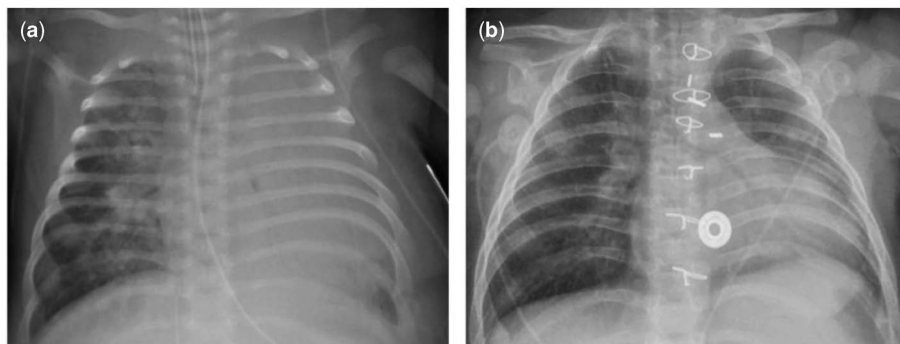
Serial chest radiographs of the patient performed at (a) the time of admission to our hospital demonstrating severe atelectasis of the left lung and (b) 2 months after surgical repair demonstrating complete resolution of left lung atelectasis.
